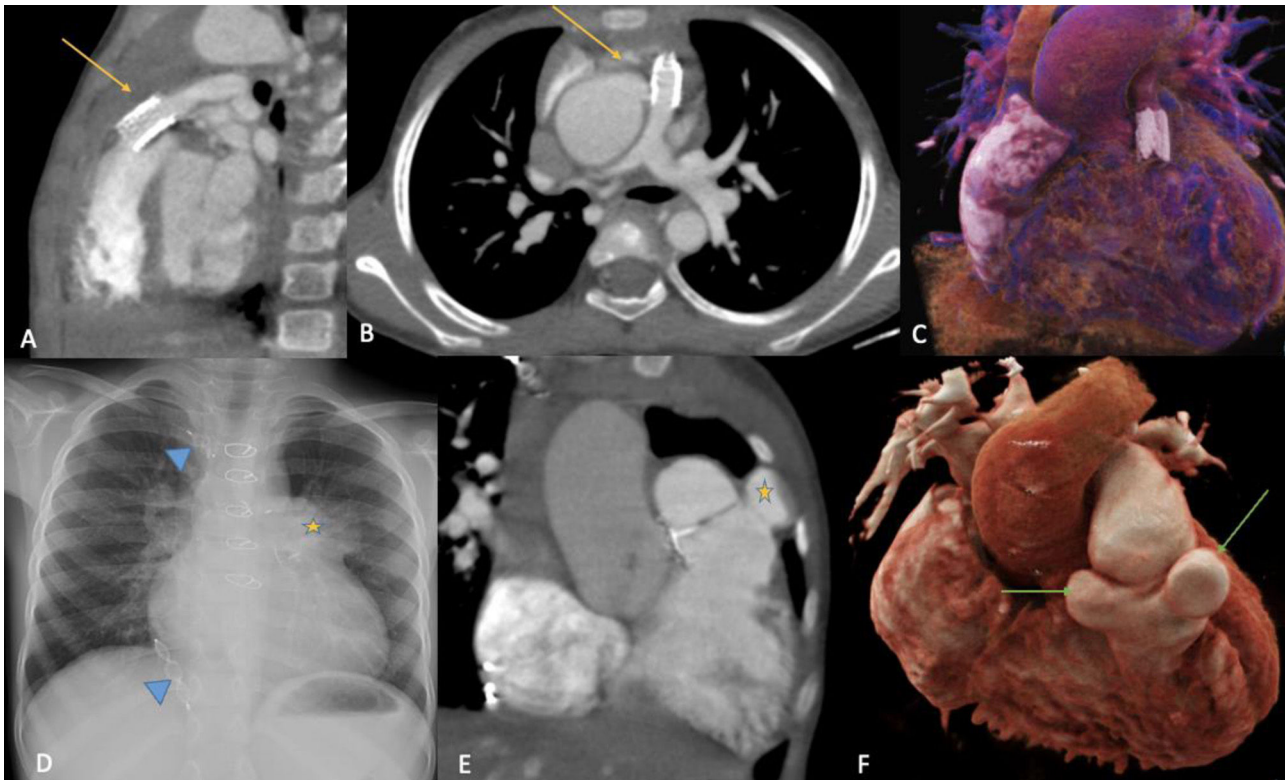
Pre- and post-operative images of a case of Tetralogy of Fallot underwent RVOT stenting followed by intracardiac repair. Preoperative cardiac CT (A–C) showing RVOT stent in situ (arrows in A and B) with good flow in main and branch pulmonary arteries. Chest radiograph (D) two years after intracardiac repair showing prominent mediastinal bulge in the location of RVOT (asterisk) with vascular plugs in the aortopulmonary collaterals (arrowheads). Coronal reconstructed image (E) of cardiac CT showing pseudoaneurysms of the RVOT patch (asterisk). The reconstructed CT cinematic rendering images better depict the two mirror-image proximal suture line aneurysms (arrows in F). CT: computed tomography; RVOT: right ventricular outflow tract.
